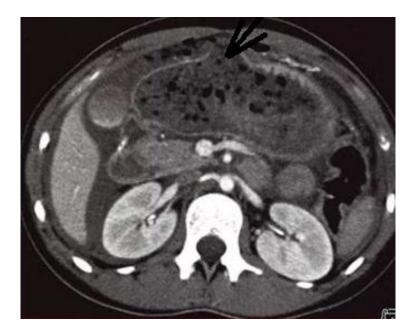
CT scan of the abdominal organs, axial projection. Visible discontinuity in the image of the anterior wall of the stomach, the release of stomach contents beyond its limits into the abdominal cavity (arrow).
